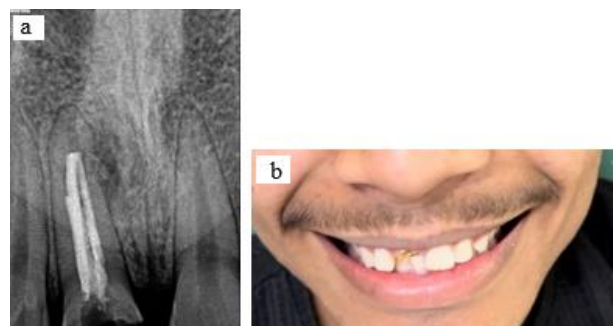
a: pre-operative radiograph; b: pre-operative clinical picture
